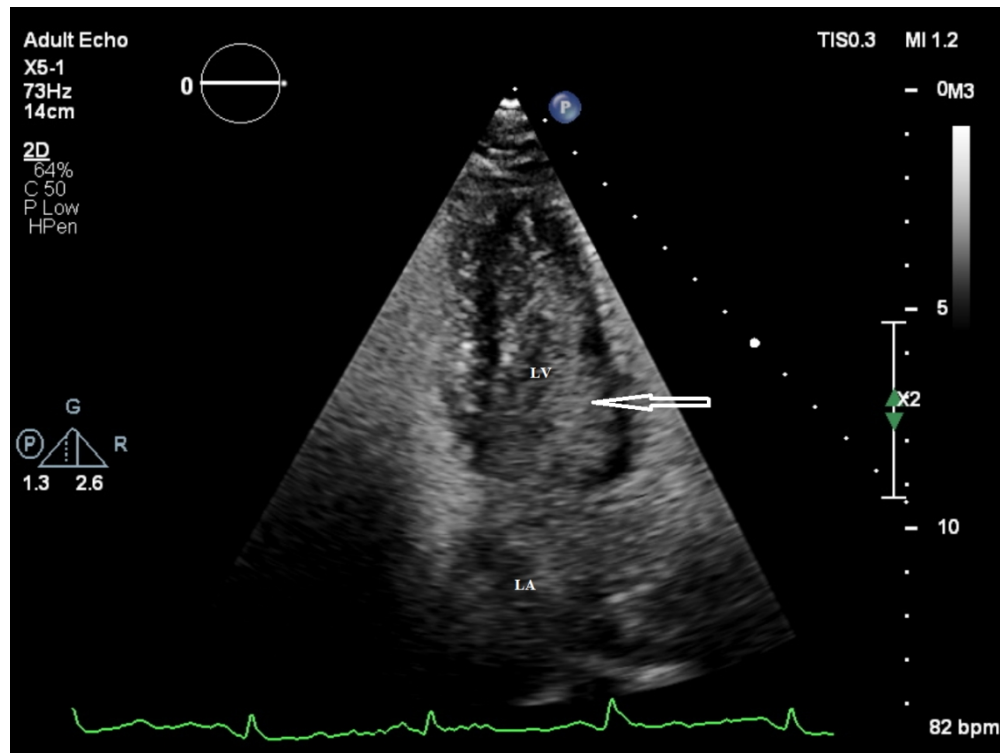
Agitated saline contrast transthoracic echocardiogram from the apical four chamber view after release of Valsalva, with contrast seen in the left ventricle within 3 RR cycles from injection (the arrow indicates the ultrasound reflected from agitated saline giving the 'white' appearance within the ventricular cavity, compared to the black myocardium adjacent). This was a large patent foramen ovale in a 58-year-old female with symptomatic severe tricuspid regurgitation and right-to-left shunting at rest resulting in hypoxia that required device closure. LV=left ventricle; LA=left atrium.
